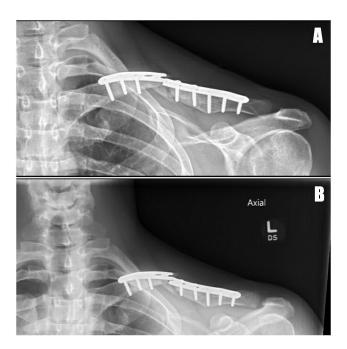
A. Xray (AP) 6 months after initial operation showing delayed nonunion at the primary fracture site and repeat plate breakage with failure of fixation; B. Xray at 7 months demonstrated no change from the previous visit.
